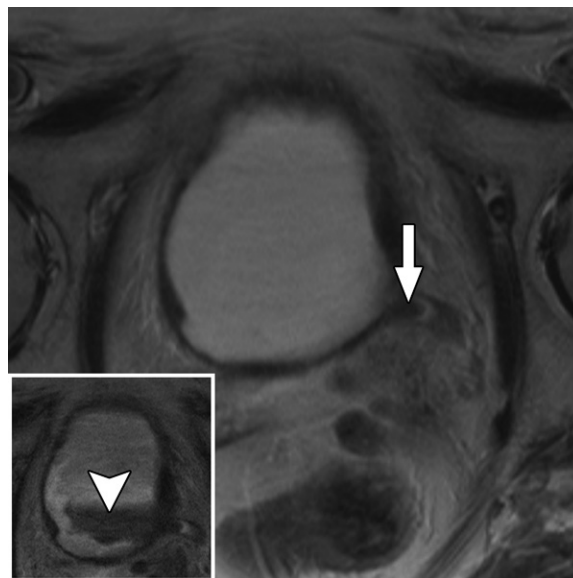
Pre- and postcontrast T2-weighted imaging of the bladder in an 87-year-old man undergoing MRI of the abdomen and pelvis. Axial T2-weighted MR image shows a left ureteral filling defect (arrow), which may be mistaken on a post-contrast T2-weighted image (inset) for excretion of concentrated gadolinium (arrowhead) into the bladder. In a bladder protocol, T2-weighted imaging should be performed before the administration of a contrast agent.
